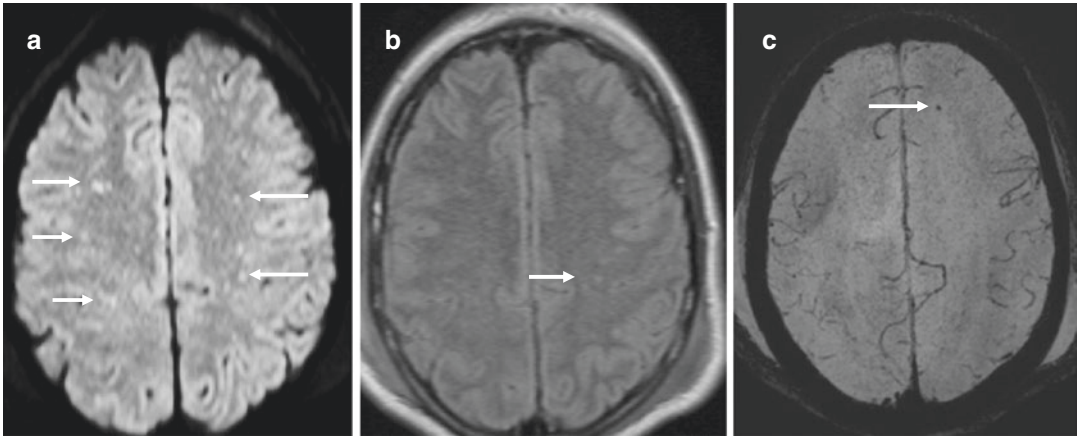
(a–c) DAI grade 1 in a 34-year-old male after MVA. CT head was negative (not shown). (a) DWI shows multiple tiny foci of RD (decreased ADC not shown) in bilateral cerebral hemispheres. (b) FLAIR shows fewer lesions which are very subtle. (c) SWI shows only one
